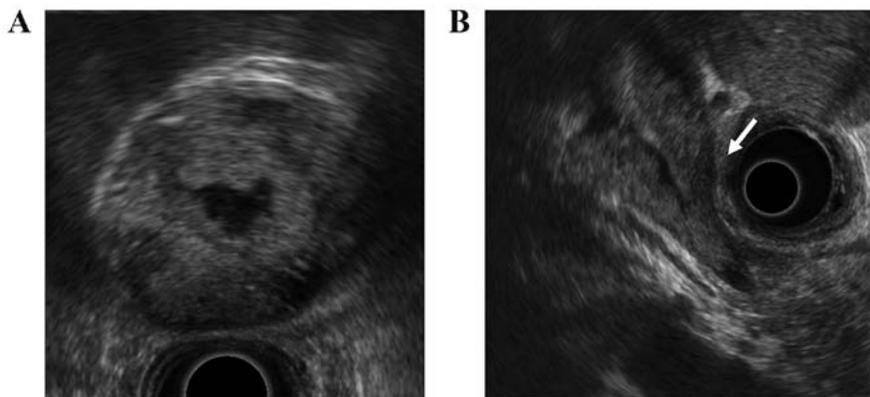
Findings of EUS. (A) EUS demonstrated polypoid lesions (B) extending from the gallbladder into the common bile duct (arrow) without invasion of the gallbladder wall or the bile duct. EUS, endoscopic ultrasonography.
